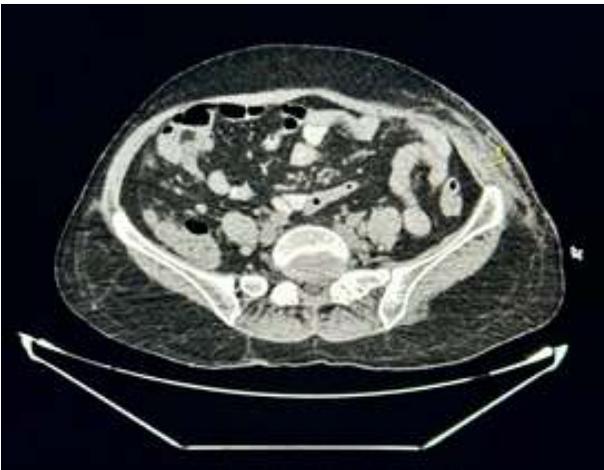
CT Scan image of the patient showing increased thickness of the anterior abdominal wall muscles in the left side (thickness of 1 cm marked in the image)
